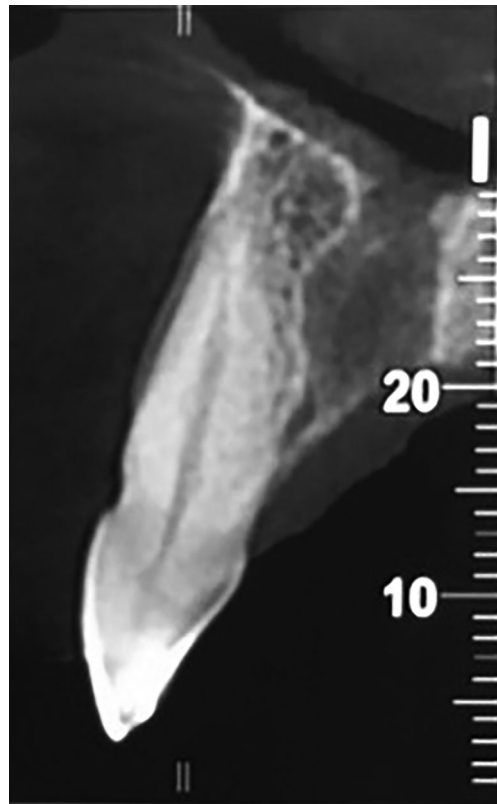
Two-year follow-up CBCT showing the reconstruction of the buccal bone wall.
